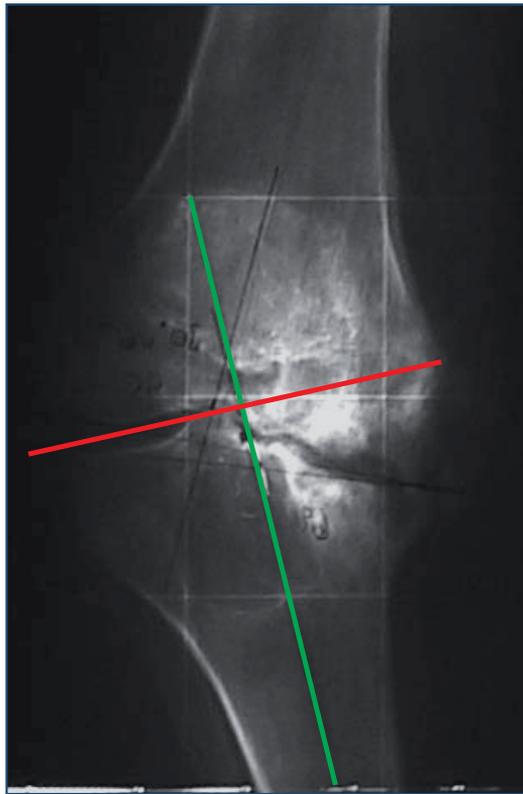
Wedge and modular extension stems should be considered in patients which present with a such pre-operative radiograph.
